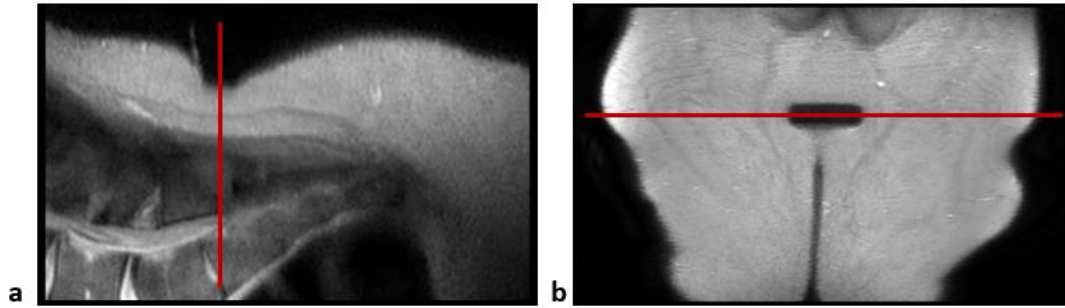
Red line marks the plane of interest on two MRI slices a) Sagittal slice; b) Frontal slice of the MR image
